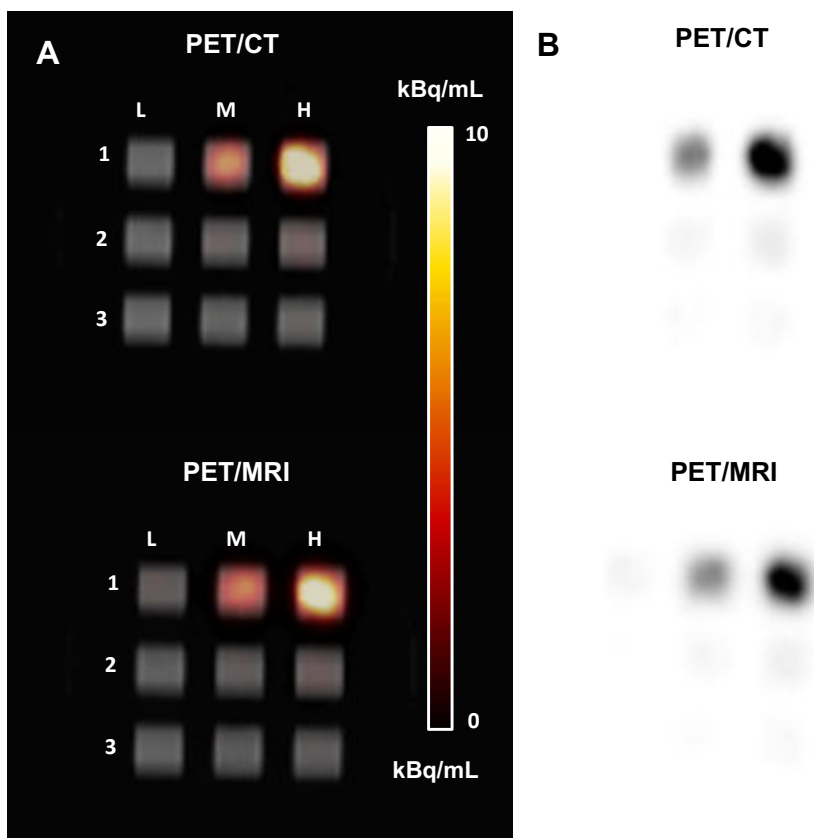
PET images of 3×3 cubic-well plate containing ^{89}Zr -labelled Jurkat cells suspended in Geltrex™ matrix in a 1 cm³ cube acquired using (A) PET/CT and PET/MRI fusion images and (B) PET images in grey-scale. Cell numbers and specific activities per well (kBq/ 10^6 cells; indicated in parenthesis) were as follows:
